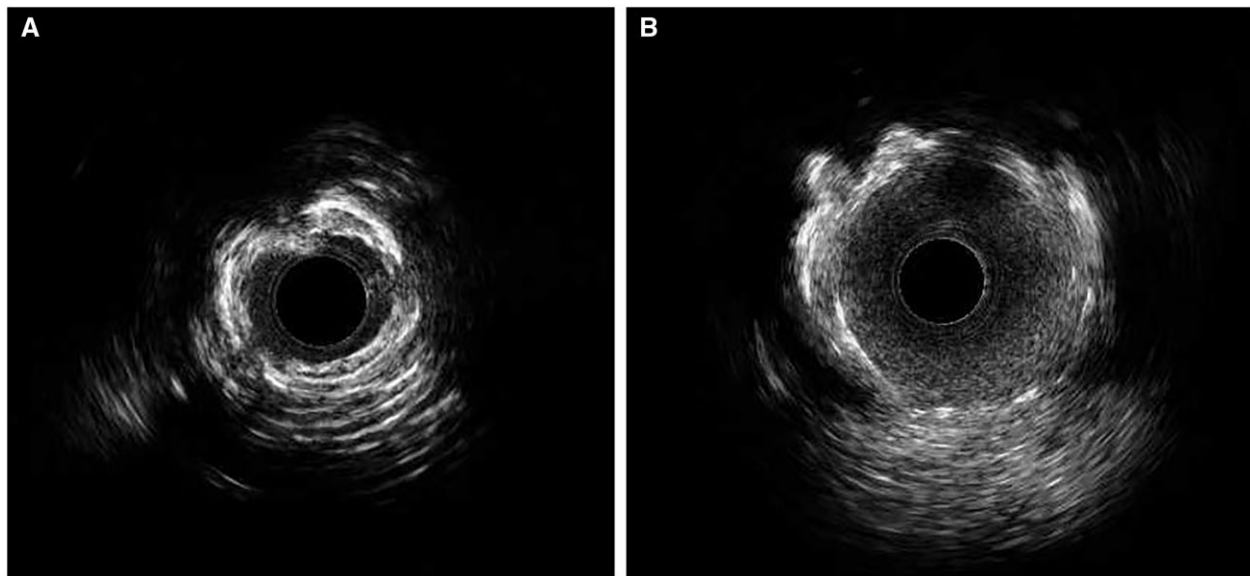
Intravascular ultrasound (IVUS) before and after intravascular lithotripsy. (A) Intravascular ultrasound showing a heavily circumferential (360°) calcified plaque as the reason of stent underexpansion (minimum stent area 1.98 mm²). (B) Intravascular ultrasound showing optimal stent expansion (minimum stent area 6.92 mm²) after intravascular lithotripsy and 3.25 mm non-compliant balloon dilatation at 8 Atm.
